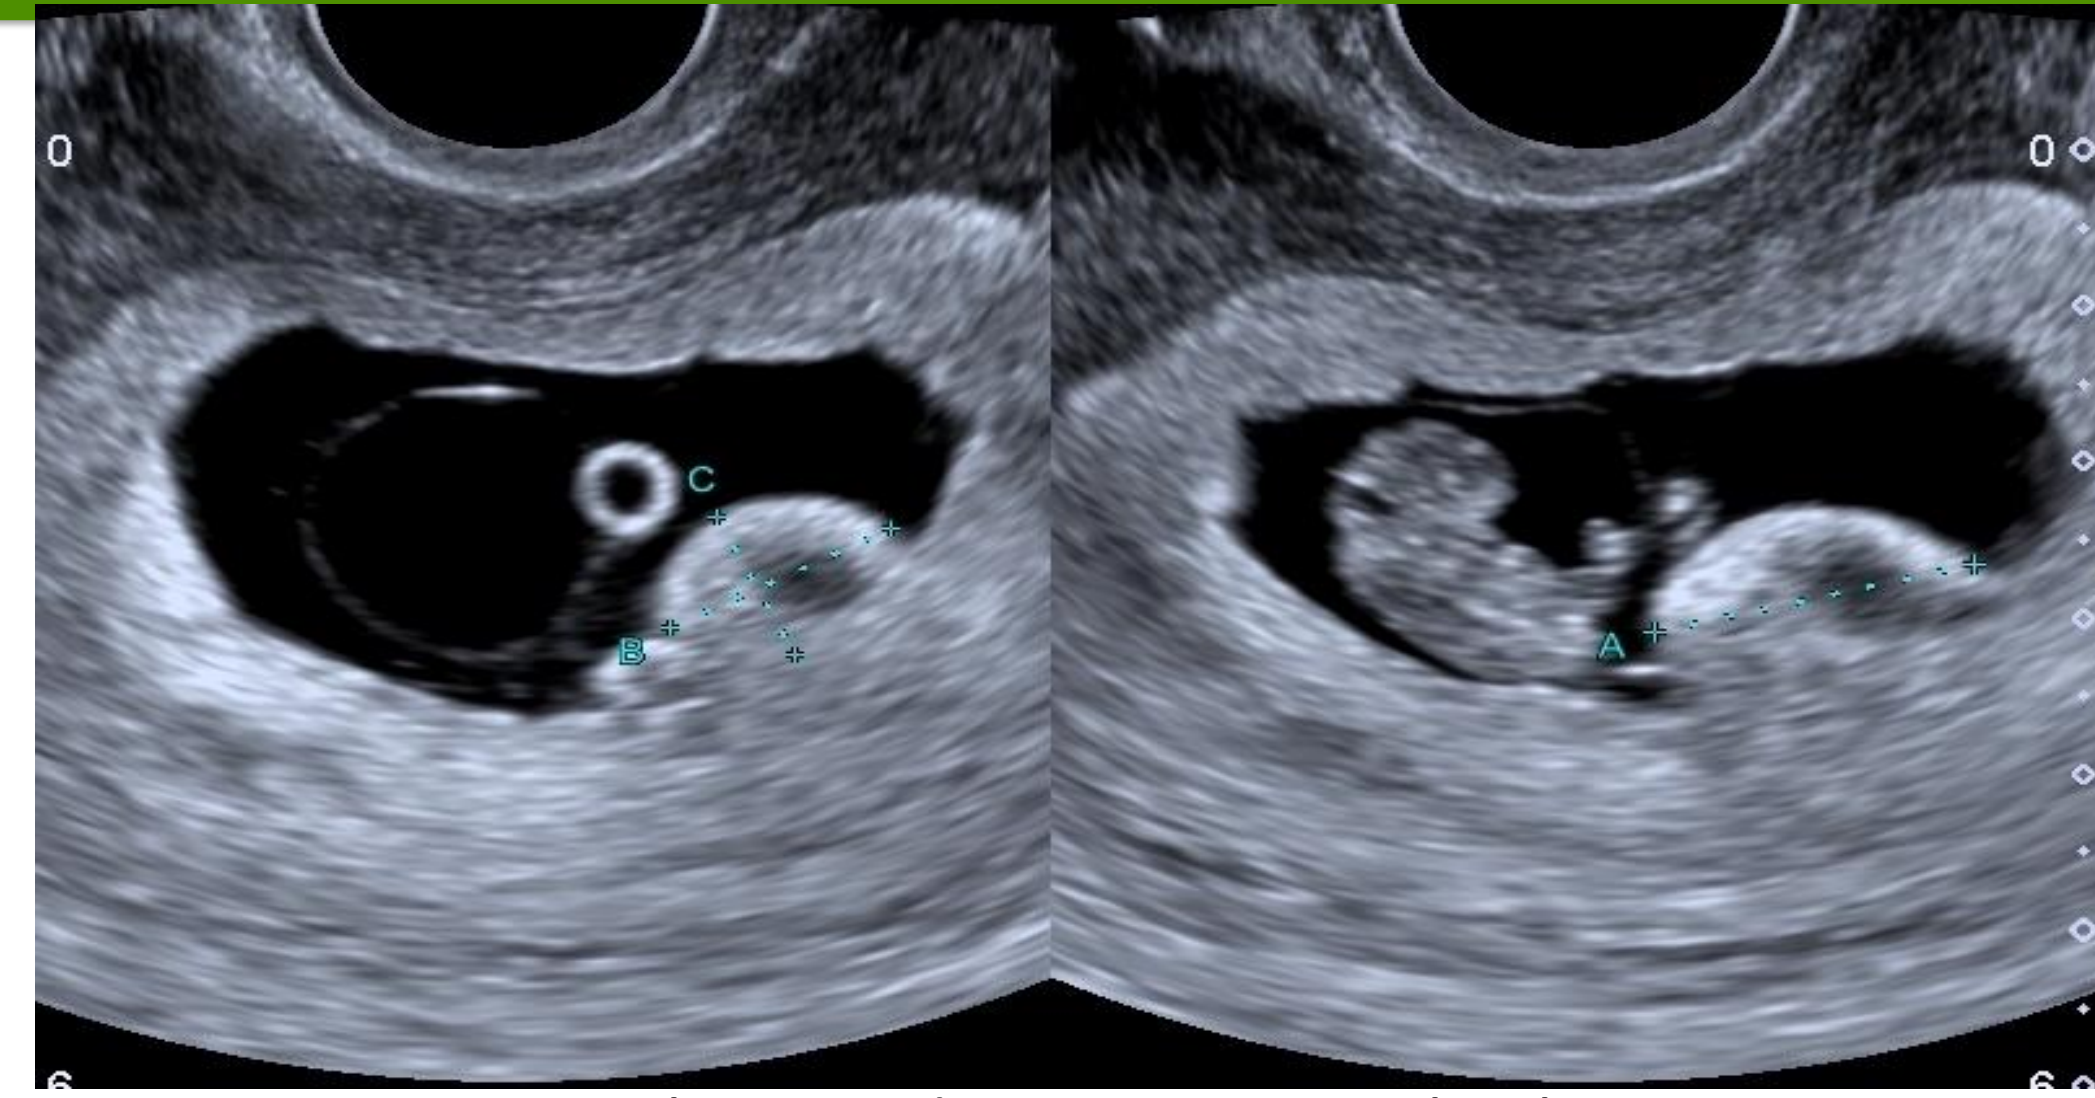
Ultrasound image at 8 weeks showing the yolk sac, fetal pole and the chorionic bump
